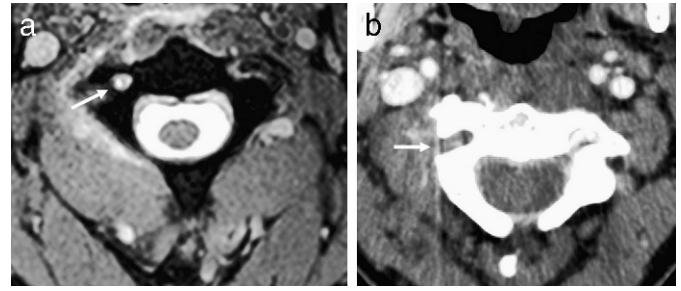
Vertebral artery injury. (a) Axial T2-weighted image shows loss of the normal flow void within the right vertebral artery (arrow). (b) Lack of right vertebral opacification is also seen on the axial CT angiogram in the same patient (arrow).
